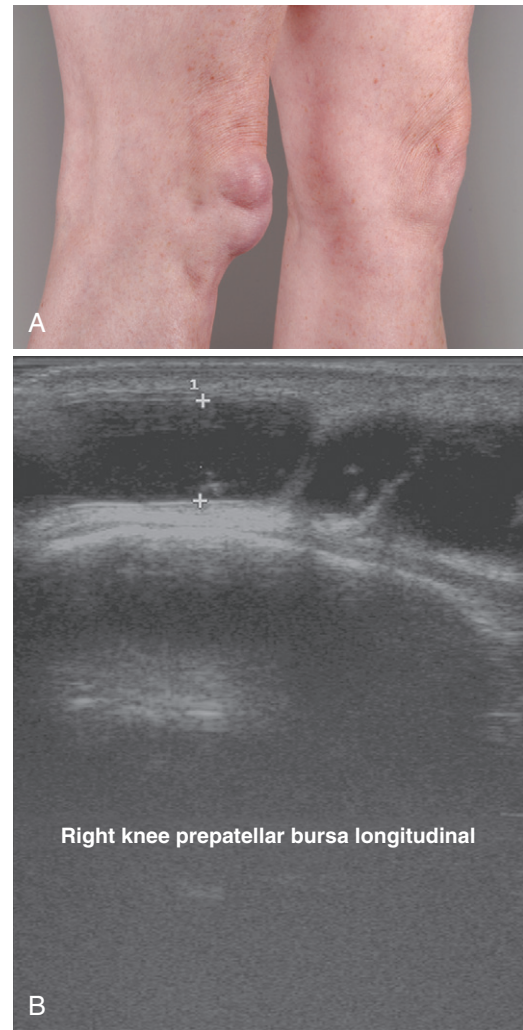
Prepatellar bursitis. A, Note the cystic swelling overlying the right patella with the appearance of two separate compartments of bursal swelling. B, High-resolution ultrasound image of the same patient showing collection of anechoic fluid with an internal septation.
